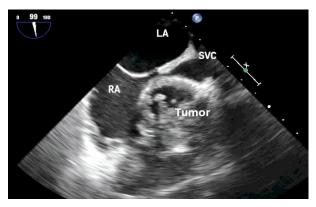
Transesophageal echocardiography mid-esophageal bicaval view showing the tumor compressing both right atrium (RA) and SVC. Abbreviations-SVC= superior vena cava, LA= left atrium, and RA= right atrium
